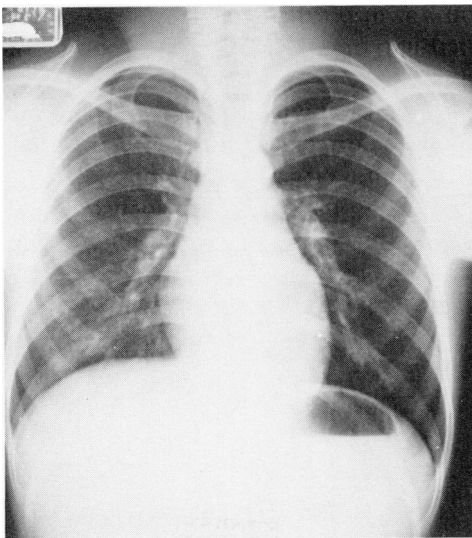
Chest X-ray film one month later (Case 2).
